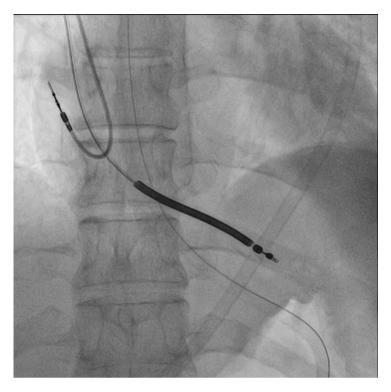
Fluoroscopy image of ICD leads after MRI scan
